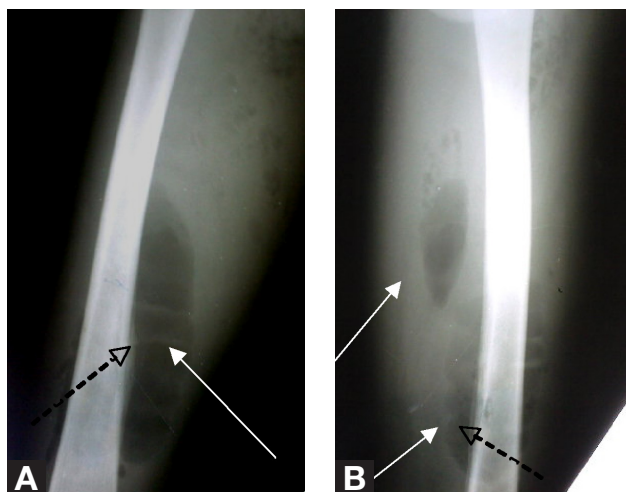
Anteroposterior (A) and lateral (B) radiographs of right thigh show gas in thigh (arrow) and periosteal reaction (dotted arrow).
